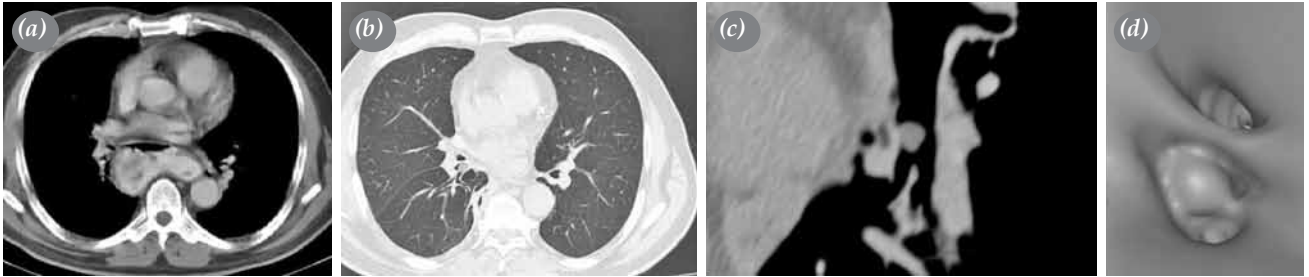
(a) Computed tomography section showing esophageal diverticulum hiding endobronchial mass. (b) After excision of diverticulum, a well-demarcated polypoid mass is seen in right pulmonary lower lobe bronchus, in axial images and (c) oblique coronal reformatted images and (d) virtual bronchoscopic images in thorax computed tomography.
